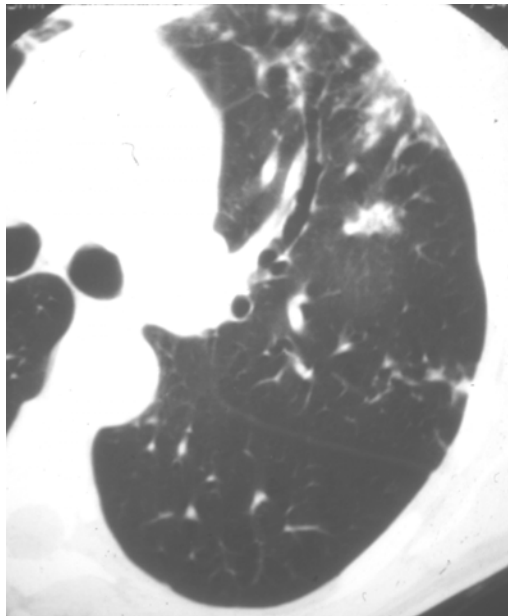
High resolution computed tomography scan of a patient with PEM lung disease demonstrating lingular bronchiectasis, nodules, and infiltrates.
